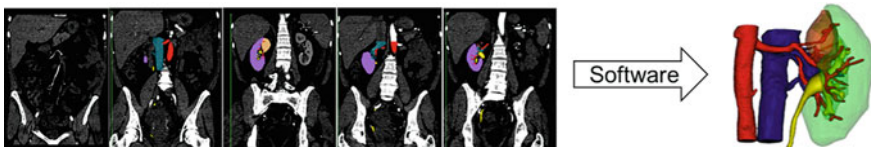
Segmentation is the process where the 3D model maker goes through the entire CT scan using a software package and indicates relevant structures for each slice
